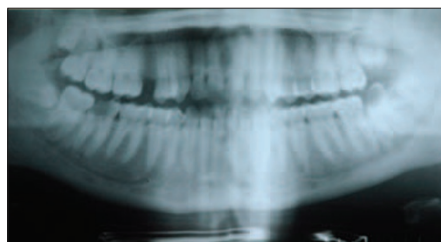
Panoramic radiograph showing the presence of bilateral impacted fourth molars
